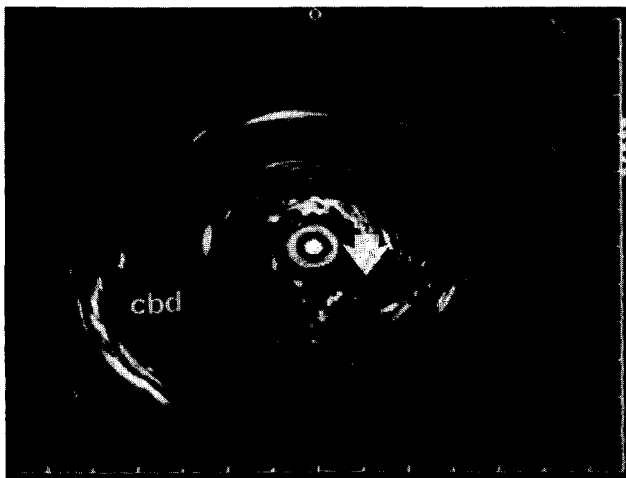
This asymptomatic patient had diffuse adenomatous change of the ampulla. Assessment with a high frequency ultrasound miniprobe (12 MHz Olympus/Keymed) inserted into the pancreatic duct confirmed a T3 lesion (arrow) extending from the ampulla to the pancreas and a dilated common bile duct (cbd).
